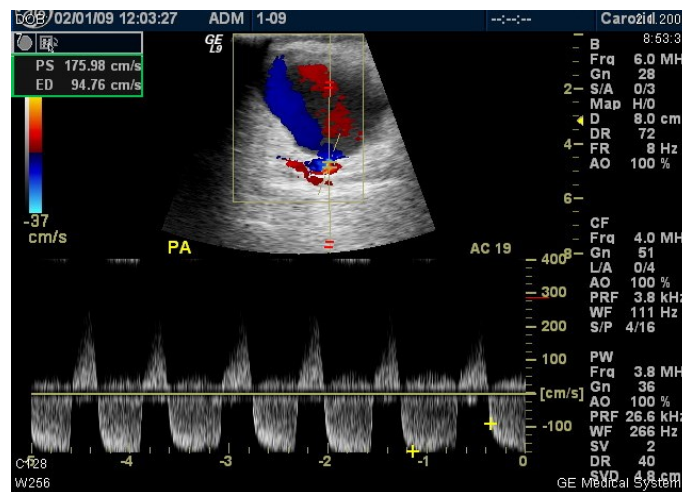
Same patient. Typical to-and-fro Doppler spectrum in the neck of the PSAN. Same patient like in the Figure 19.
